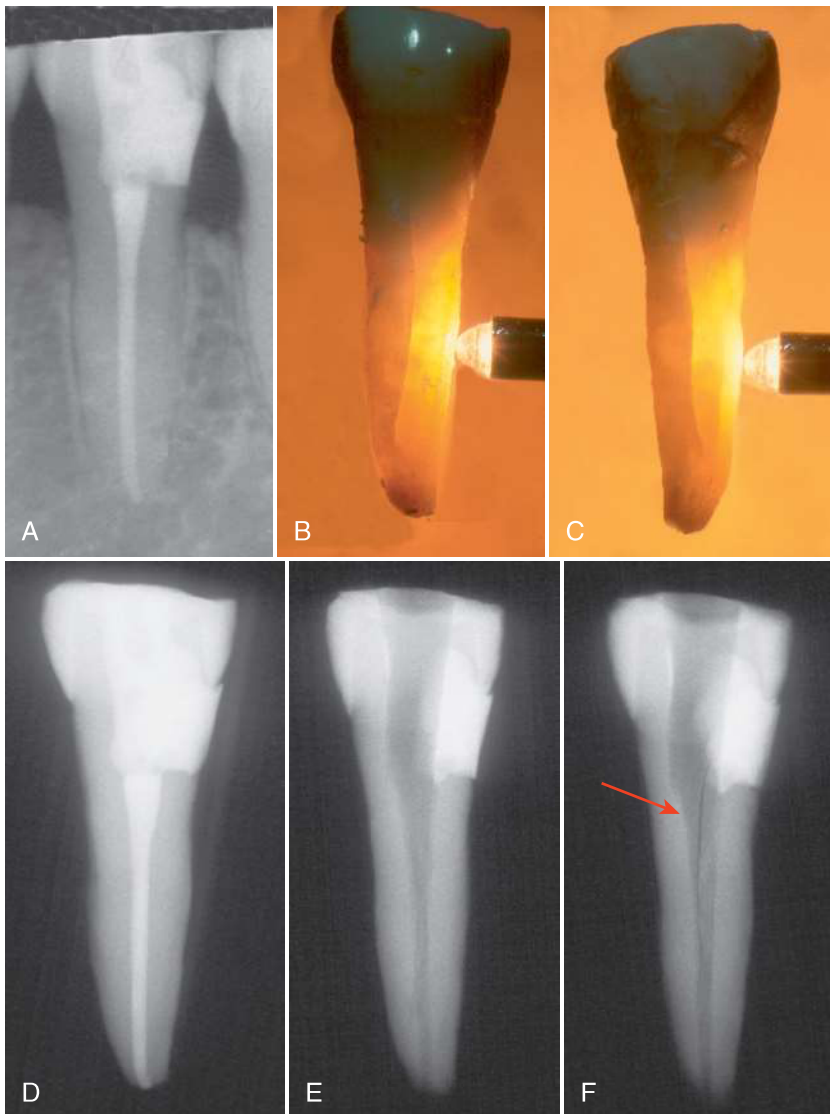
Radiography of an ex vivo empty canal. The second left mandibular bicuspid underwent a root canal treatment, with no post required. Thirteen months later, the patient complained about pain and sensitivity to palpation on the lingual side. A radiograph provided no further information (A). An isolated, 7-mm pocket was detected on the lingual side, and the tooth was extracted. Midroot VRFs were visible on the buccal (B) and lingual sides (C). An ex vivo radiograph of the same tooth with no findings (D). The root filling was removed, and radiographs were taken from different mesiodistal angulations (E, F). One of the radiographs clearly revealed the VRF (F).
